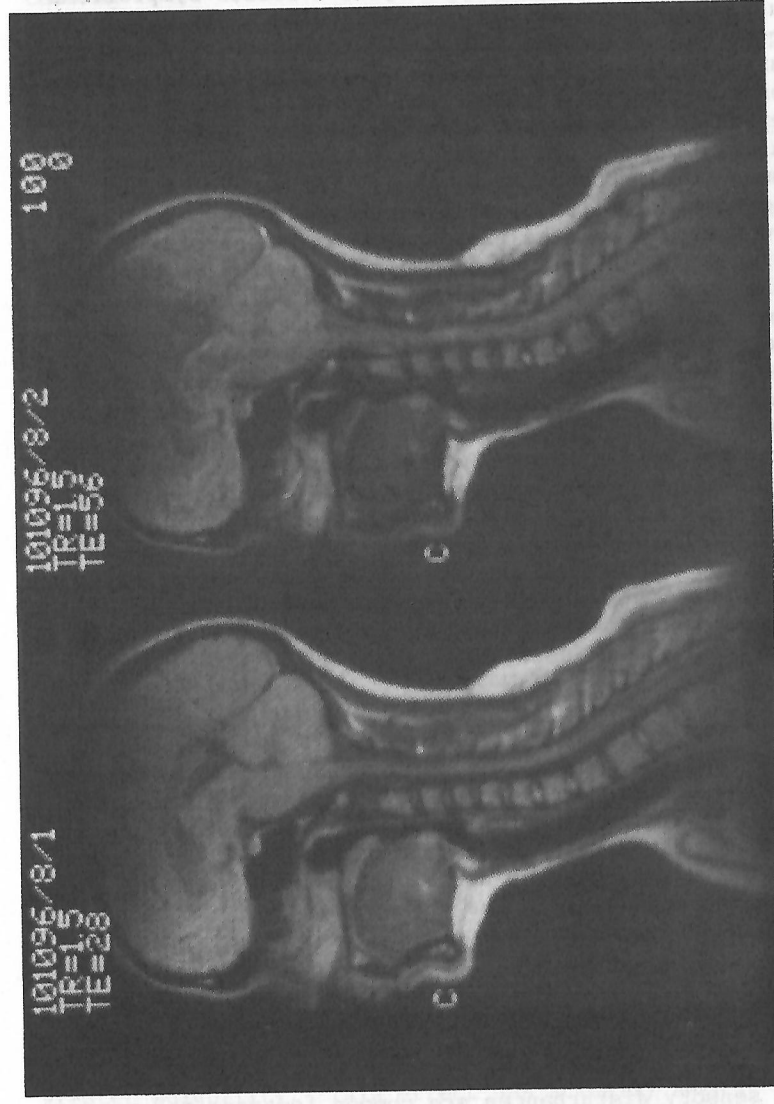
Magnetic Resonance Images of a female amateur diver (28 yrs.) who flew about 11 hours after a dive to about 90ft (30m) for 40 minutes.
